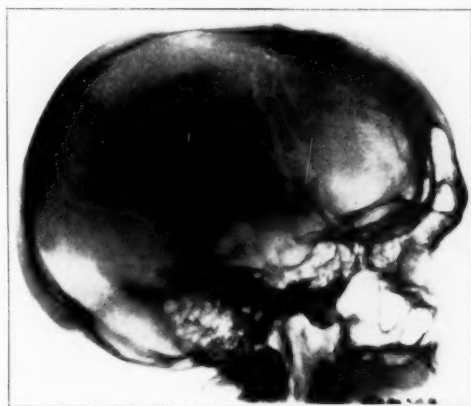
(case 1).—Roentgenogram showing a benign bilateral hyperostosis associated with a fibroblastoma in the frontal region.
